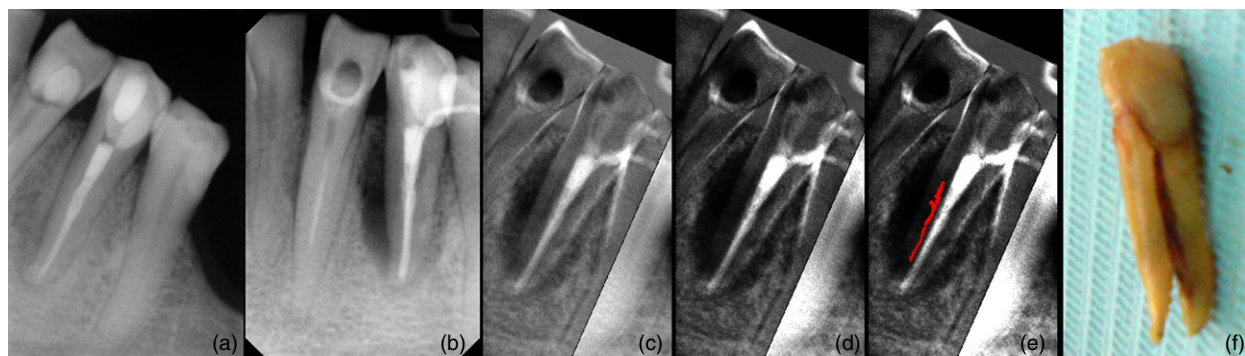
(a) Post-operative radiograph. (b) 3 years later: radiolucency in the proximal area and the apical third of the distal area. No fracture line can be observed. (c) Result of digital subtraction of b from a: a dark line in the body of the root at its mesial part is visible. (d) DSI processed using CET. (e) Image d processed using PCT. (f) VRF in the extracted tooth.
